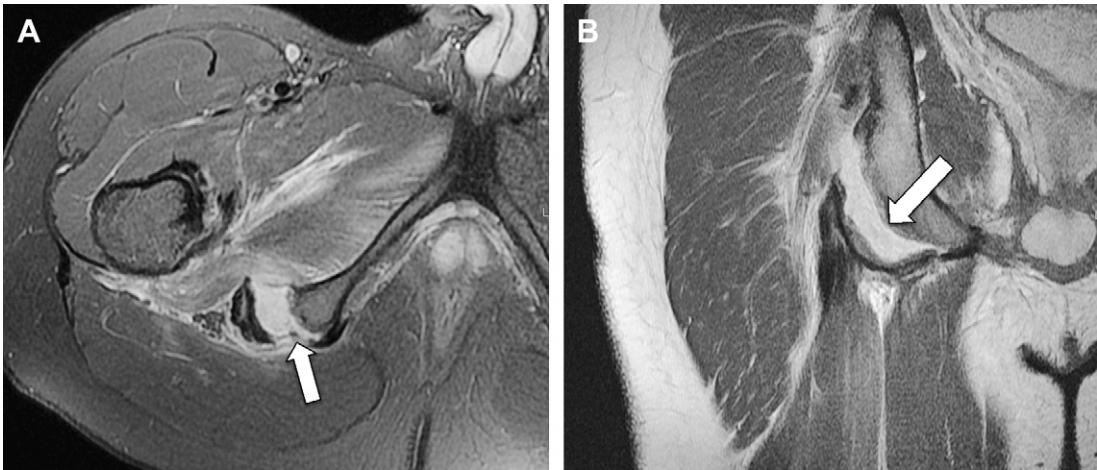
(A) Axial fat-saturated T2-weighted MR image of a 12-year-old patient shows an avulsion at the attachment of the hamstring to the ischial apophysis on the right (arrow). (B) Coronal T1-weighted image of same patient demonstrating the hamstring avulsion injury (arrow).
